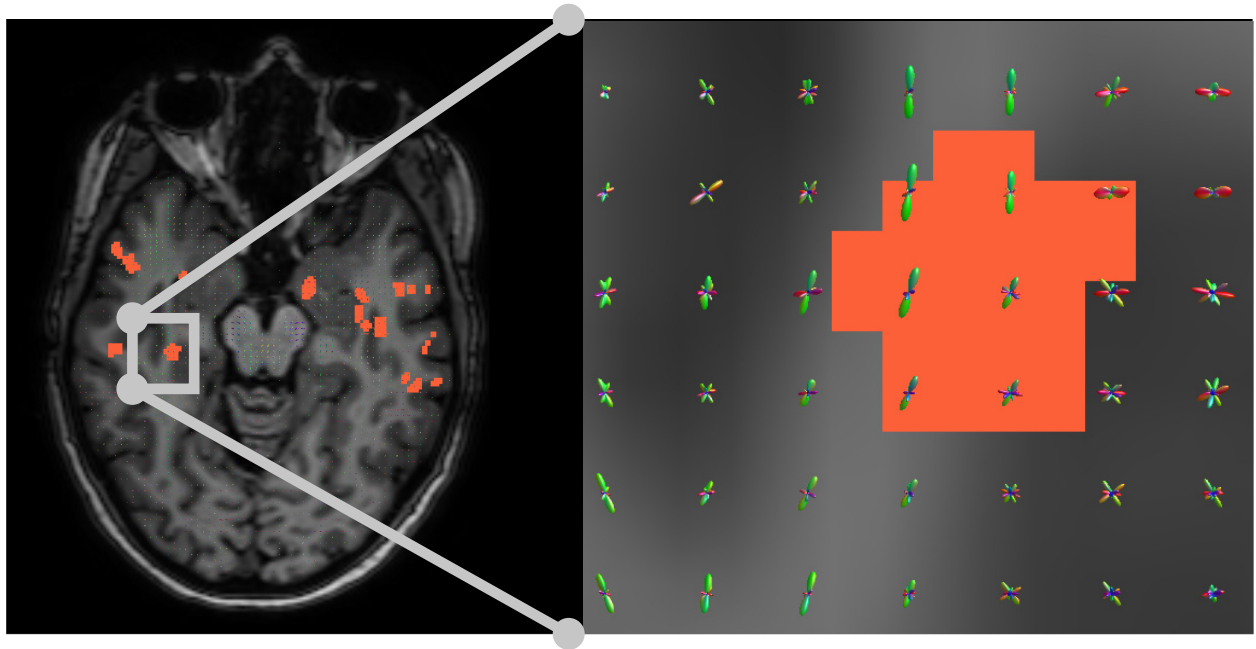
Fiber orientation distributions (FODs) displayed as an overlay on the MRI DWI. The electrode contact areas are displayed in orange. The shape of the FODs in and around the electrode contact area show that the area is located on the grey-white matter boundary. The grey matter is located on the left and upper right of the electrode contact area.
